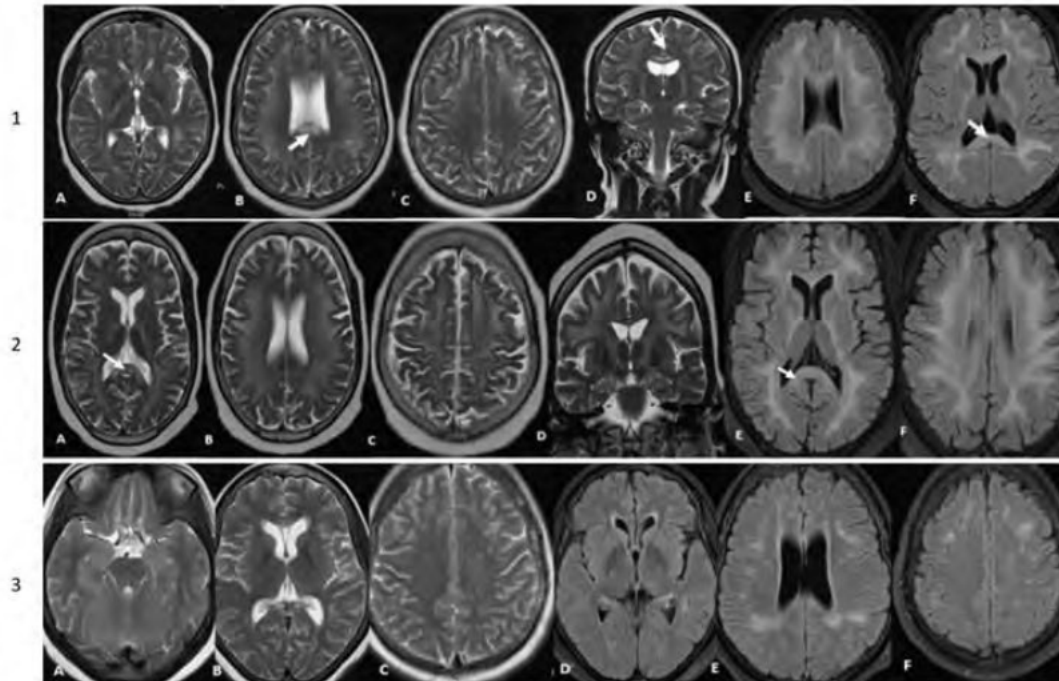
(Patient 1 during a relapse) and Image 2 (Patient 2: pre-treatment): Diffuse T2 (A-D) and T2 FLAIR (E, F) symmetrical white matter hyperintensities involving the bilateral hemispheres and the splenium and genu of the corpus callosum(arrows).Image 3: Post-treatment images of patient 2: T2 (A, B, C) and T2 FLAIR (D, E, F) demonstrating significant resolution of previous white matter hyperintensities seen in image 2.
